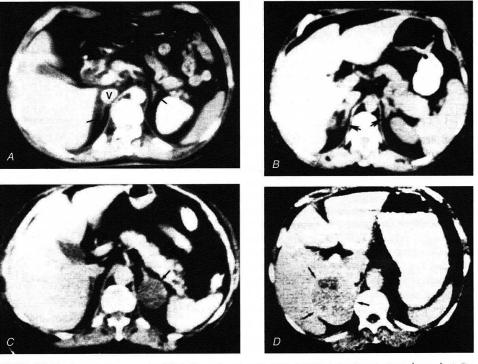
Computed tomography (CT) is the preferred method for visualizing the adrenal glands (*arrows*). *A*. The normal right adrenal gland is adjacent to the inferior vena cava (V) where it emerges from the liver. Approximately 90% of right adrenal glands appear as linear structures extending posteriorly from the inferior vena cava into the space between the right lobe of the liver and the crus of the diaphragm. The normal left adrenal gland is lateral to the left crus of the diaphragm and below the stomach. Most left adrenal glands are shaped like an inverted V or Y. *B*. Adrenal CT scan of a patient with ectopic ACTH production. Both adrenal glands (*arrows*) are enlarged (compare with *A*). In contrast, only 50% of patients with bilateral adrenal hyperplasia secondary to pituitary ACTH hypersecretion show enlargement of the adrenal overproduction. The left adrenal has been replaced by a racquet-shaped 2-cm tumor (*arrow*). Attenuation of the tumor is low because of its high lipid content. *D*. CT scan in a patient with Cushing's syndrome and biochemical evidence of an adrenal carcinoma. In contrast to the tumor in *C*, the right-sided mass in this patient is large and has a heterogeneous appearance—usual characteristics of an adrenal carcinoma.
